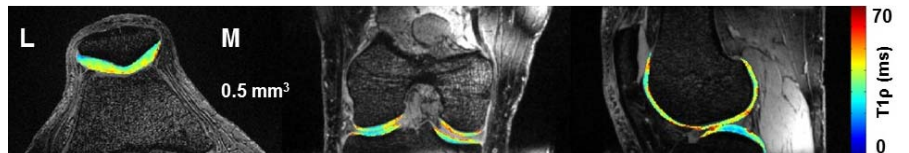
Axial, reformatted - coronal and sagittal sections of the healthy knee showing $T_{1\rho}$ maps acquired using 3D isotropic MRI.
